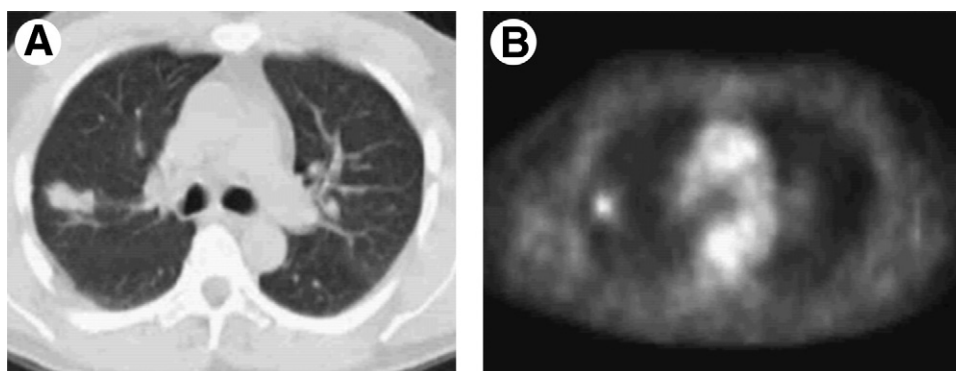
(A) CT and (B) FDG-PET scan of a 51-year-old man with a benign nodule that resolved after antibiotic therapy. By use of CT features, the computed likelihood of malignancy was improved (decreased) from 0.78 (an indication of cancer, PET alone) to 0.29 (an indication of a benign nodule, PET + CT).
